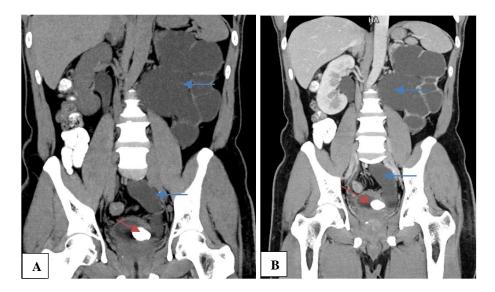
(A) In the coronal reformated images of un enhnaced phase of CT urography showing left VUJ calculus (red arrow) casuing gross hydroureteronephrosis (blue arrow); (B) in the coronal reformated MIP images of nephrogenic phase of CT urography showing left VUJ calculus casuing severe hydroureteronephrosis (blue arrow).
